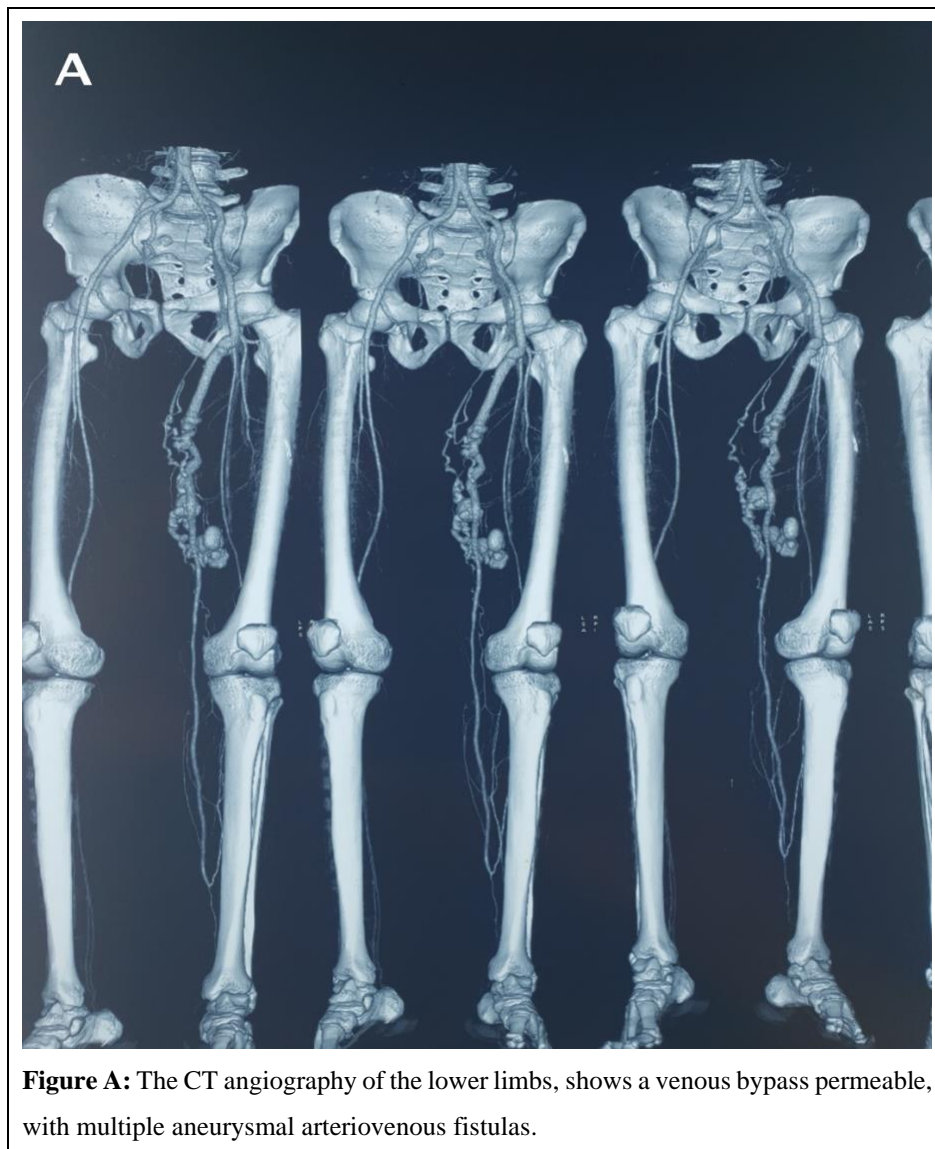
The CT angiography of the lower limbs, shows a venous bypass permeable, with multiple aneurysmal arteriovenous fistulas.
